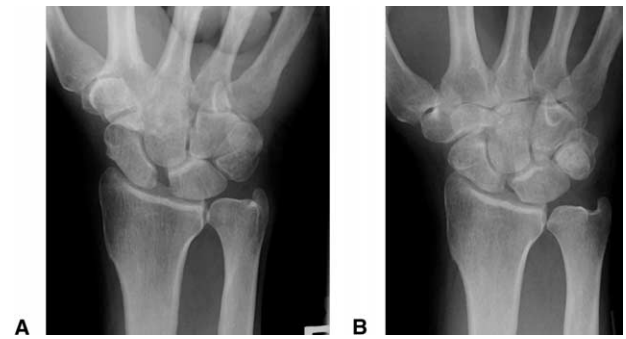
(A) Preoperative PA grip-view radiograph and (B) PA grip-view radiograph at 44 months after surgery of patient 6. Although gapping of the SL interval still can be seen the patient is symptom free and no arthritic changes to the wrist are noted.
